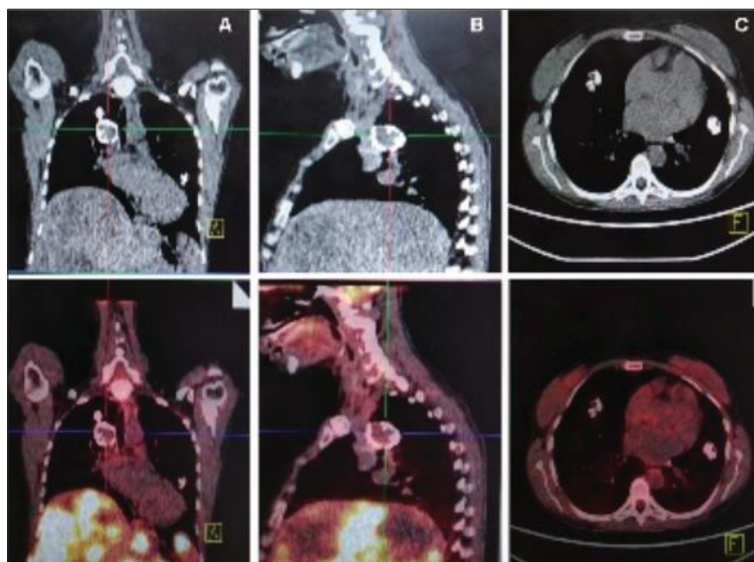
A – coronal, B – sagittal, C – axial CT, fused PET/CT (mediastinal window) images of bilateral pulmonary chondromas
